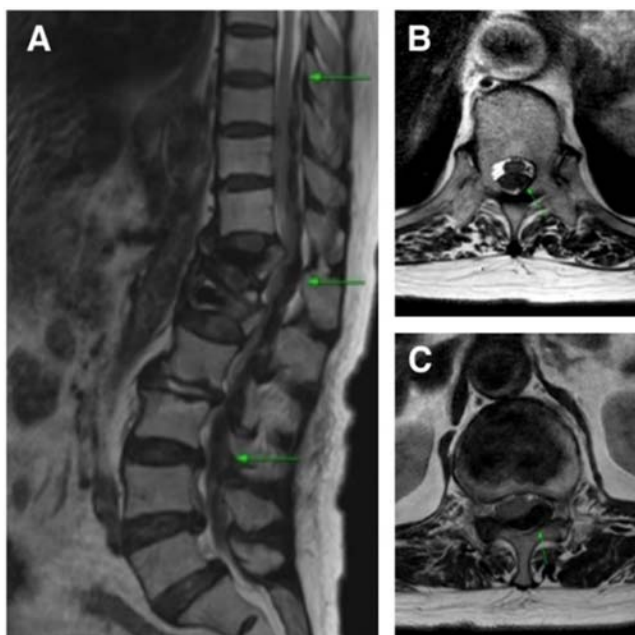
T2-weighted magnetic resonance images of thoracolumbar spine showing an acute spinal epidural hematoma (SEH) performed on February 17, 2022. The image on the left (A) is the sagittal view with spinal cord compression at the T8–L4 level (green arrows). The image on the right side (B, C) is the axial view of the SEH. The image on the right upper side (B) is at the T9–10 level, and the right lower side (C) is at the T12–L1 level. The scan shows distended epidural space with low signal (green arrow).
